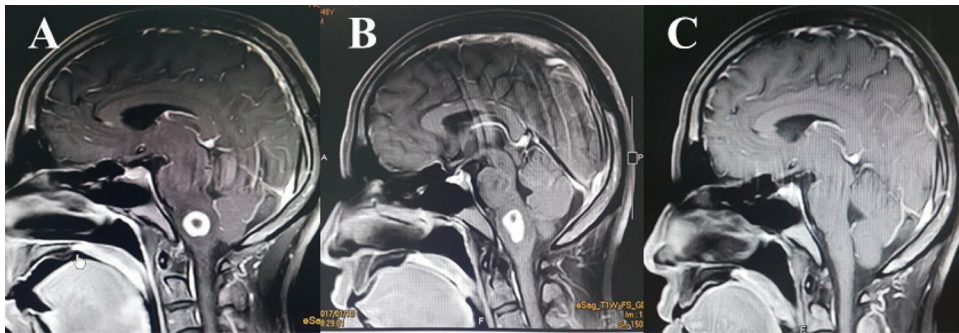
(A) T1-weight Gd-enhanced sagittal MRI showed lesion at medulla. (B) T1-weight Gd-enhanced sagittal MRI at 4 months showed enlargement of lesions. (C) T1-weight Gd-enhanced sagittal MRI after complete treatment showed disappearance of lesion.
